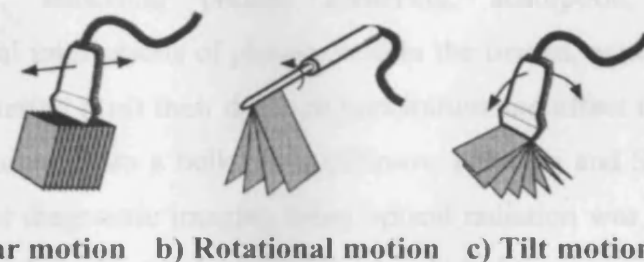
Different types of probe motion used in 3-D ultrasound imaging (Harvey et al., 2002)
